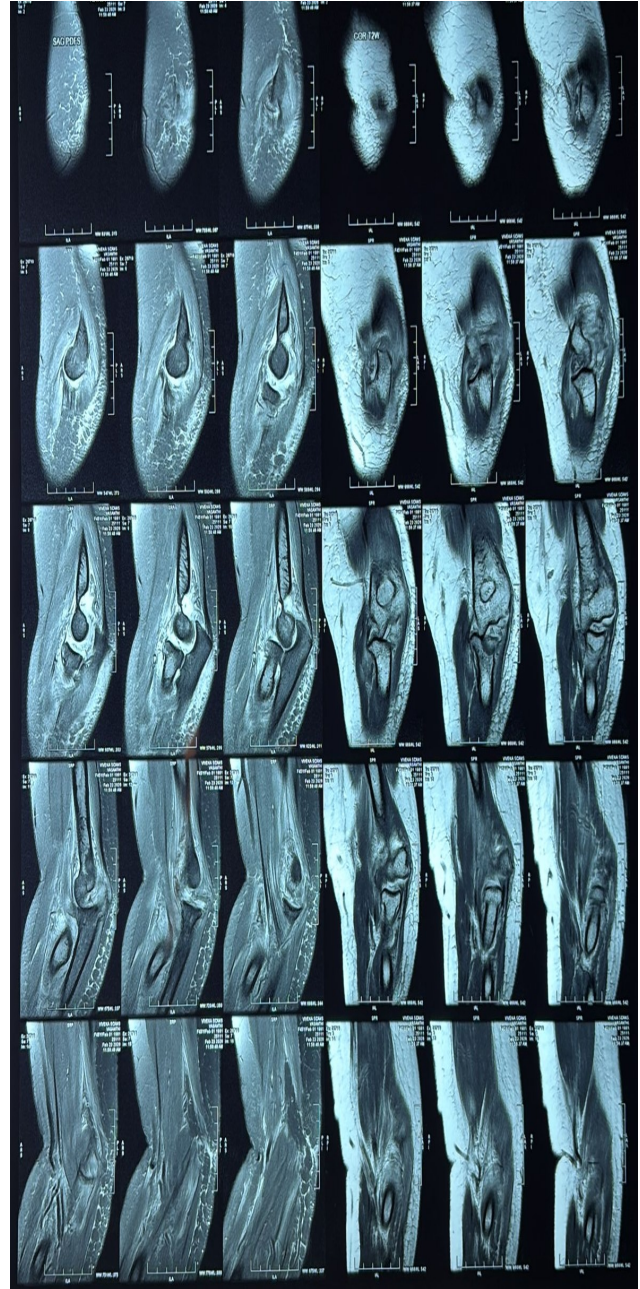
MRI left elbow — sagittal PDFS and T2W sequences demonstrating posterior and lateral subluxation of the elbow joint, anterior radial head dislocation, and significant periarticular effusion with synovial thickening.
